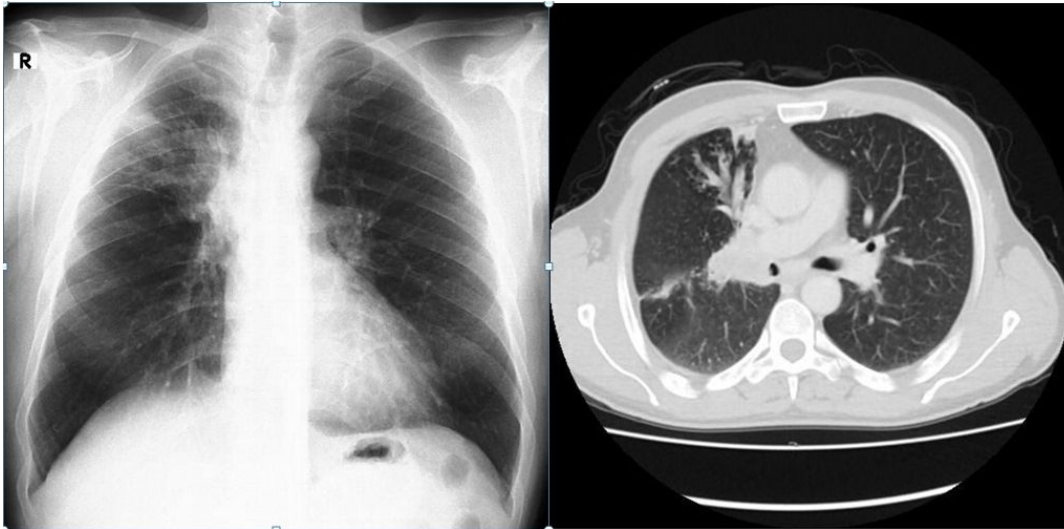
Chest X-ray and mass lesion in computed tomography of thorax
